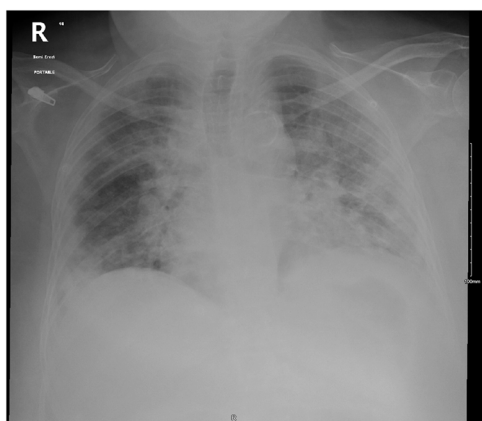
Chest X-ray (during admission). There were bilateral patchy airspace opacities that were predominantly peripheral, with blunting of the CP angles.
